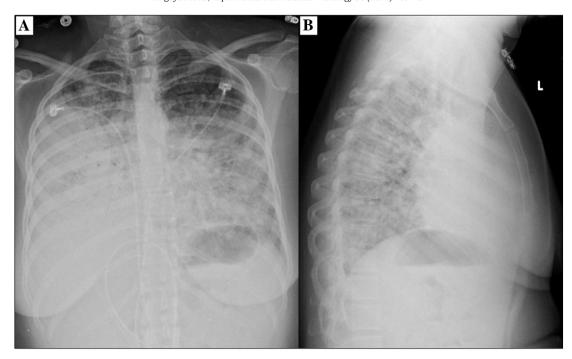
PA (A) and lateral (B) chest X-ray on presentation showing dense perihilar opacities in both lungs. The pulmonary vasculature is mildly prominent.
